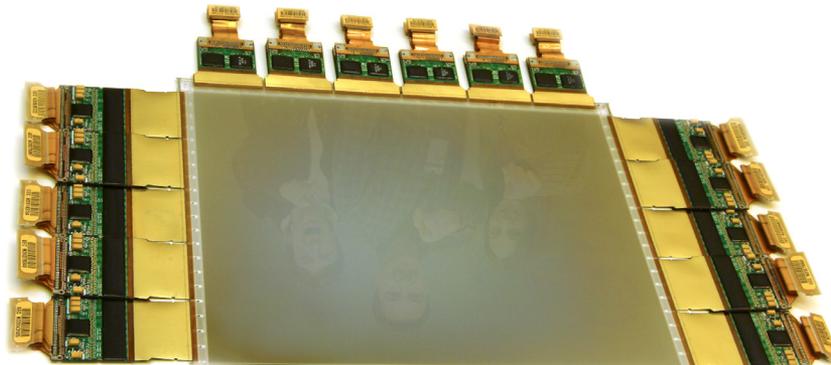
High-resolution amorphous silicon flat-panel x-ray detector for digital mammography. Detector elements (pixels) are 0.1 mm on a side. A CsI(Tl) phosphor is evaporated onto the surface to make this an x-ray sensitive device. Courtesy, General Electric Global Research Center, Niskayuna, NY.
